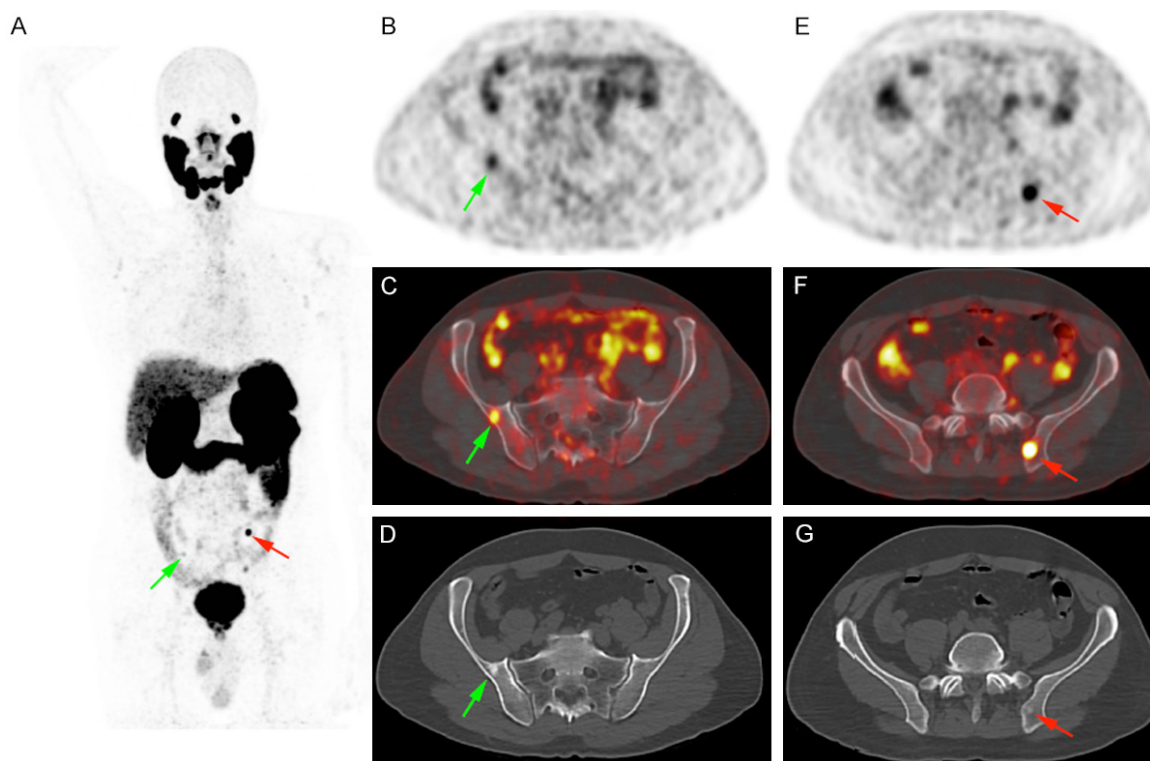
Prostate cancer staging in a 54 years old patient (Gleason score 4 + 4, PSA value: 8.6 ng/ml) showing two blastic lesions with focal [⁶⁸Ga]Ga-PSMA-11 uptake (maximum Standardized Uptake Value measured at 13). The patient underwent surgery and PSA was undetectable after surgery, proving the non-specific nature of these lesions.
